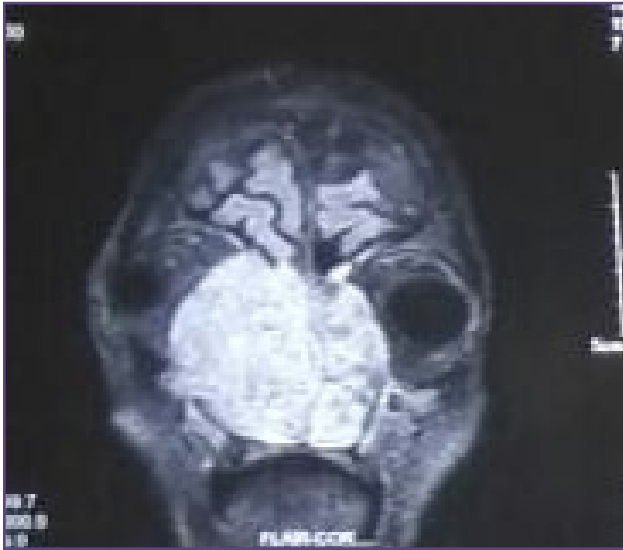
MRI suggestive of a well defined lobulated mass lesion involving the nasal cavity and bilateral ethmoid sinuses.
